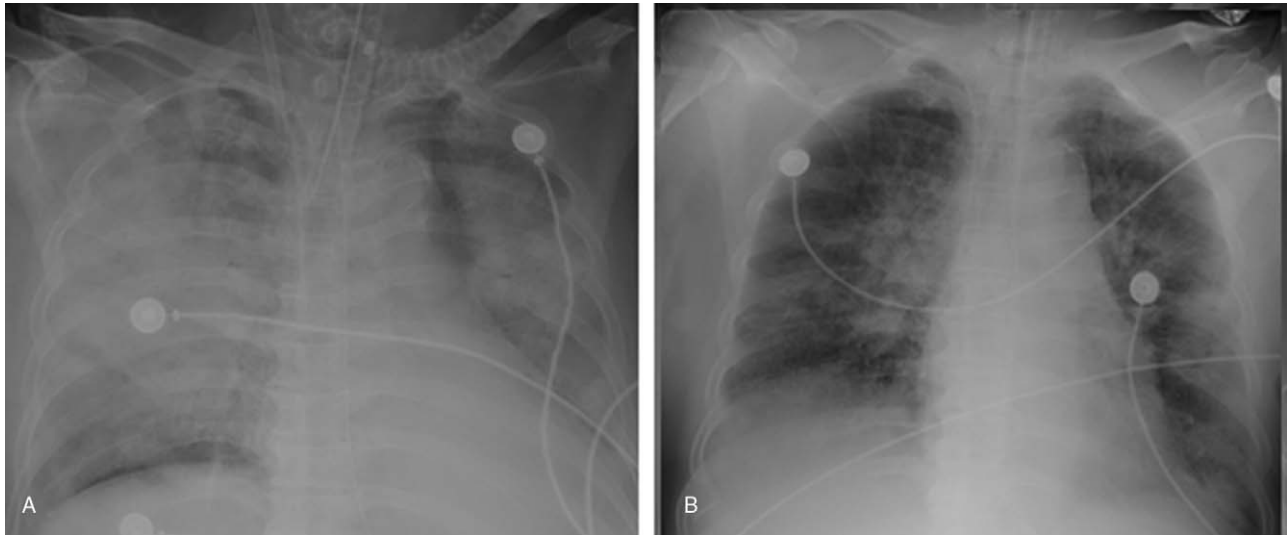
A. At 1 week from disease onset (on d 1 of admission, February 10, 2018), the chest radiography showed patchy, roundish, and sheet-like blurred shadow. B. After treatment, the chest radiography of the patient suggested that the lung shadows were significantly absorbed as compared with that before the treatment (at 3 weeks from disease onset, on d 14 of admission, February 23, 2018).
